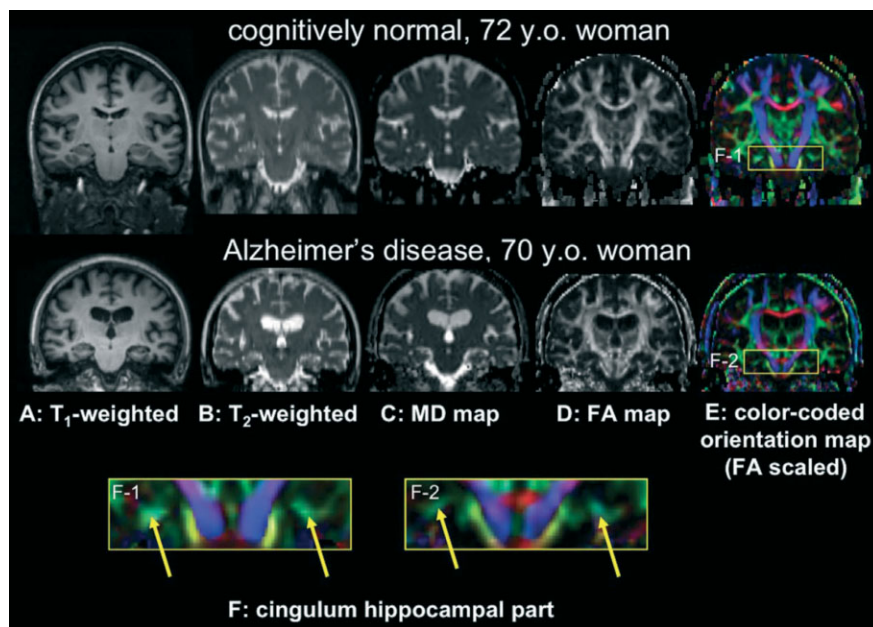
Comparison of conventional and DT-MRI of a cognitively normal 72-year-old woman (upper row) and a 70-year-old woman with AD. (A) Conventional T₁-weighted images. (B) Conventional T₂-weighted images. (C) DT-MRI-derived mean diffusivity. (D) DT-MRI-derived fractional anisotropy. (E) DT-MRI-derived color-coded orientation maps. The yellow rectangles in (E) are magnified and shown in (F), with (F-1) from the cognitively normal woman and (F-2) from the AD patient. The yellow arrows indicate the cingulum hippocampal regions. Abbreviations: AD, Alzheimer disease; DT-MRI, diffusion tensor magnetic resonance imaging; FA, fractional anisotropy; MD, mean diffusivity; y.o., year-old. Reproduced with permission from Oishi *et al.*⁷⁷
